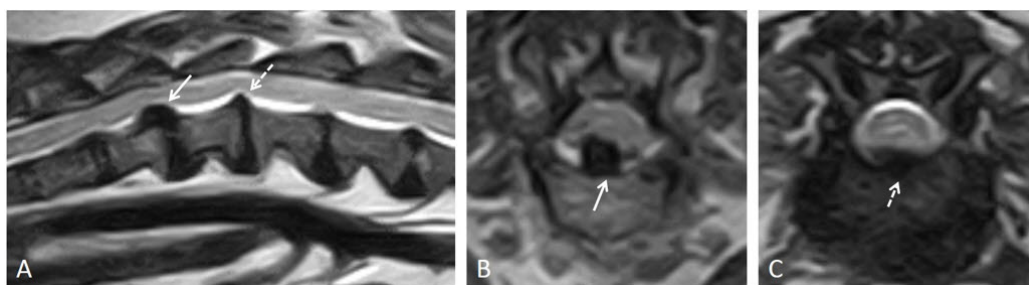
Exclusion criteria due to two intervertebral disc diseases on magnetic resonance imaging. (A) Sagittal T2-weighted image (T2WI). (B, C) Transverse T2-weighted images (T2WI). Disc extrusion (arrows) and disc protrusion (dashed arrows) are shown.
